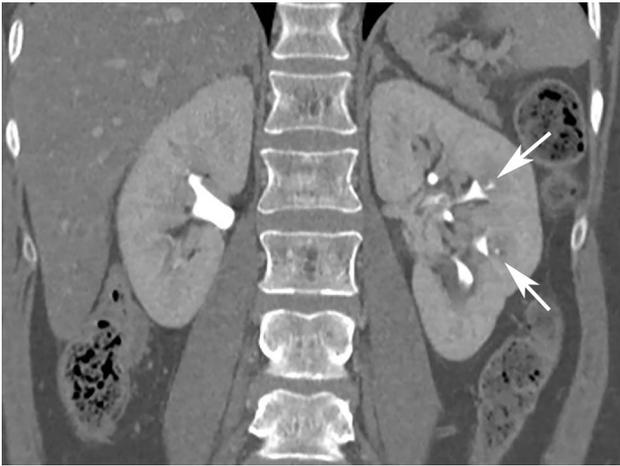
Papillary necrosis. A coronal reformatted excretory phase contrast-enhanced CT image through the kidneys shows two small high attenuation foci in the renal pyramids (arrows). The appearance is diagnostic of papillary necrosis. This finding is often overlooked on CT urography
